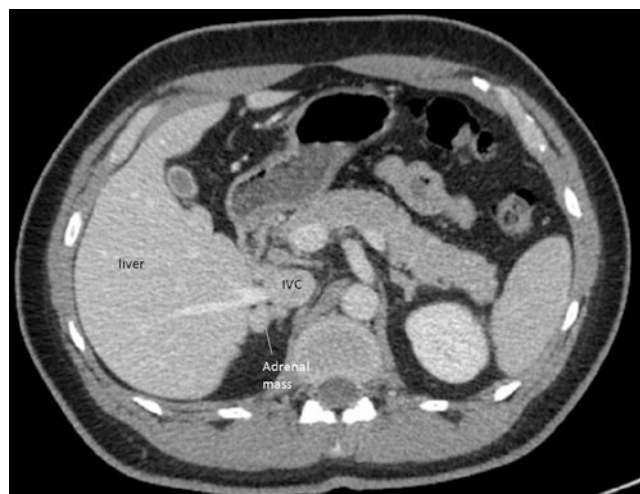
Axial view of CT scan of the abdomen demonstrating a right adrenal nodule
